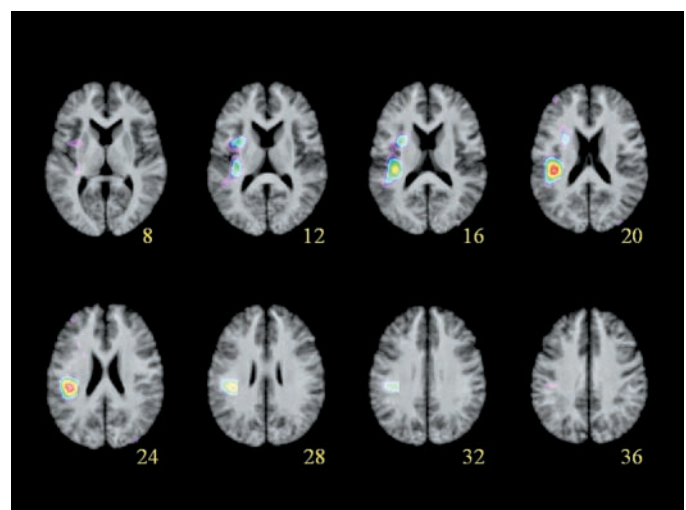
Statistical parametric map of response difference (thresholded by  $P_{\text{uncorrected}} < 0.01$ ) superimposed on the spatially standardized, averaged T1-weighted MR data of the populations. The numbers indicate the stereotactic coordinates of slices relative to the intercommissural line in vertical ( $z$ ) direction.
